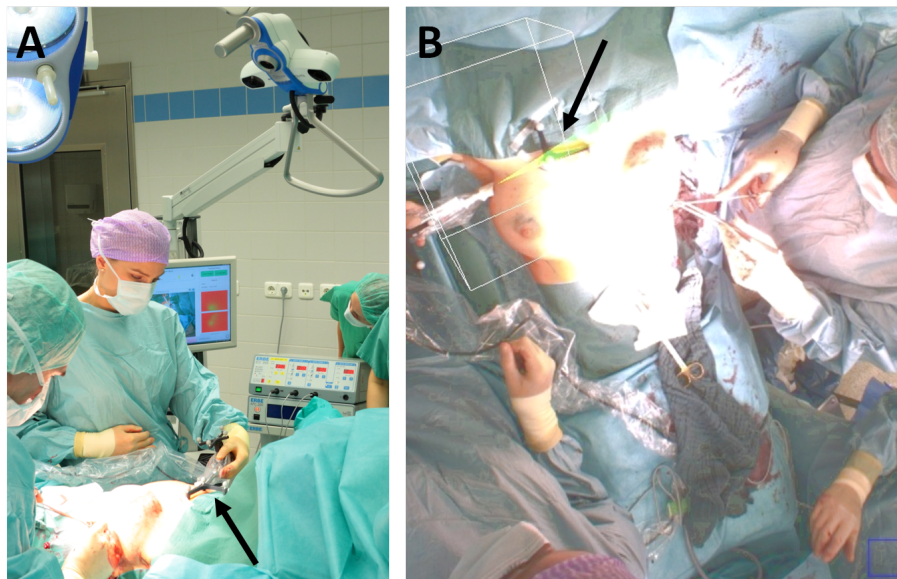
(A) outside view of freehand SPECT system looking at operating situs while doctor is scanning the right breast. In this particular case, the patient underwent an SLNB procedure with breast conserving surgery on the right breast and a mastectomy on the left side. Main surgeon started with the mastectomy during freehand SPECT scan. The arrow shows the position of the patient tracking target. (B) shows the same situation from the freehand SPECT camera. The wire-box overlaid on the patient shows the VOI for that particular image.
